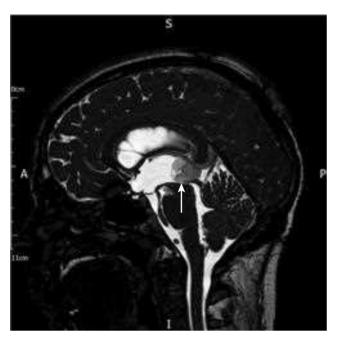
High-resolution midline sagittal T2-weighted MR image in a patient with a pinealoblastoma (arrow) obstructing the aqueduct of Sylvius causing a dilated third ventricle
